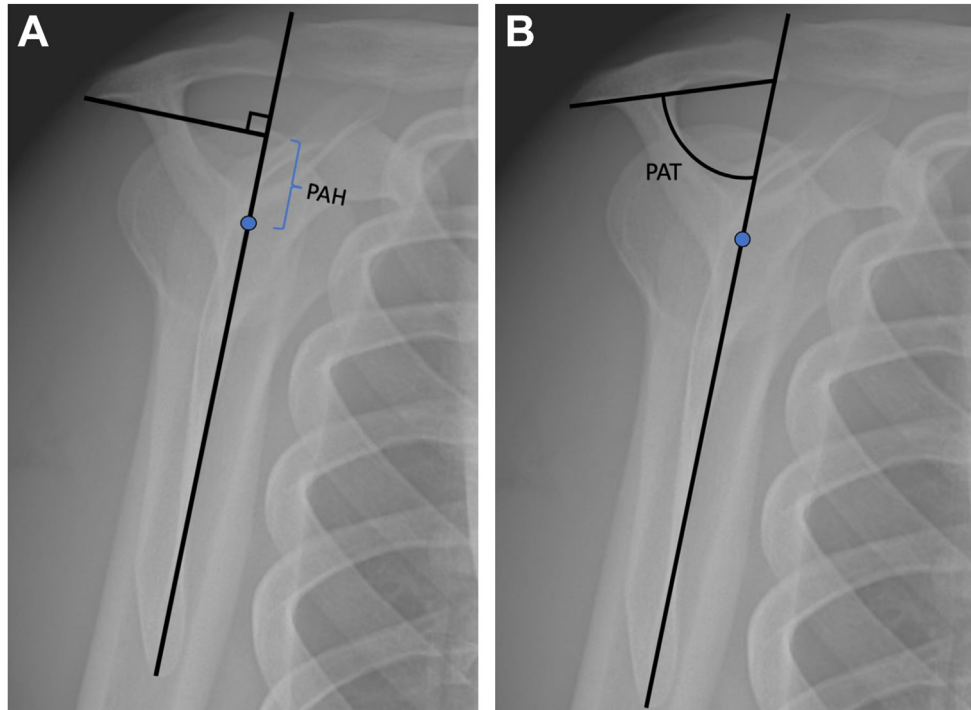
A, B: Scapular Y radiograph demonstrating the posterior acromial height (PAH) and posterior acromial tilt (PAT) measurements.
